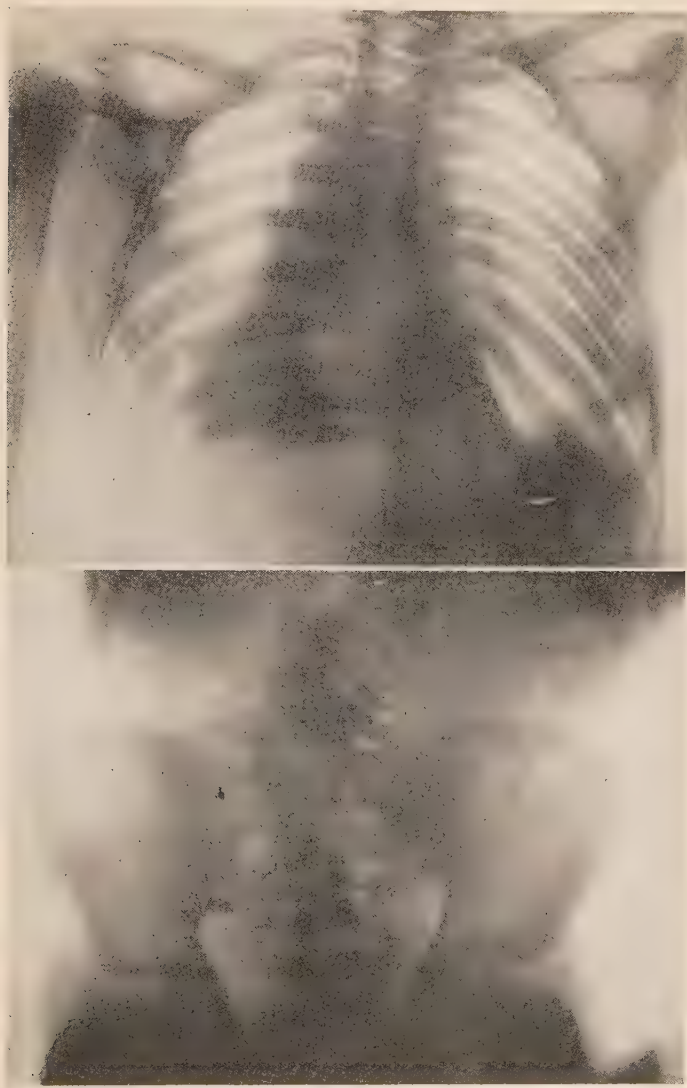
Scoliosis, on top of the sacrum is apparently a half vertebra possibly an extreme wedge-vertebra, center of column obscured by heart and liver. (*Children's Hospital, A. W. George, Radiographer.*)
